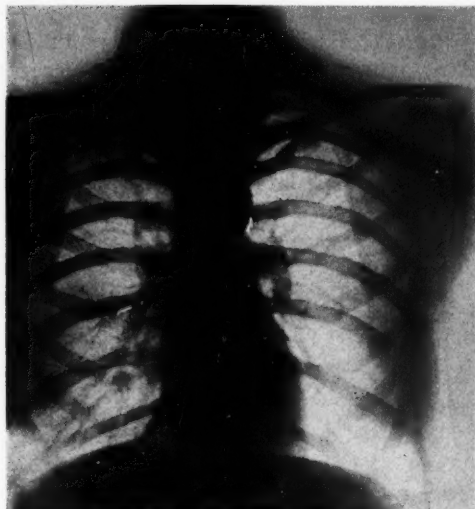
Physical signs positive: bacilli negative. Physical signs: right lung, breathing bronchovesicular, vocal resonance increased and rales to third rib. X-ray findings: negative.
